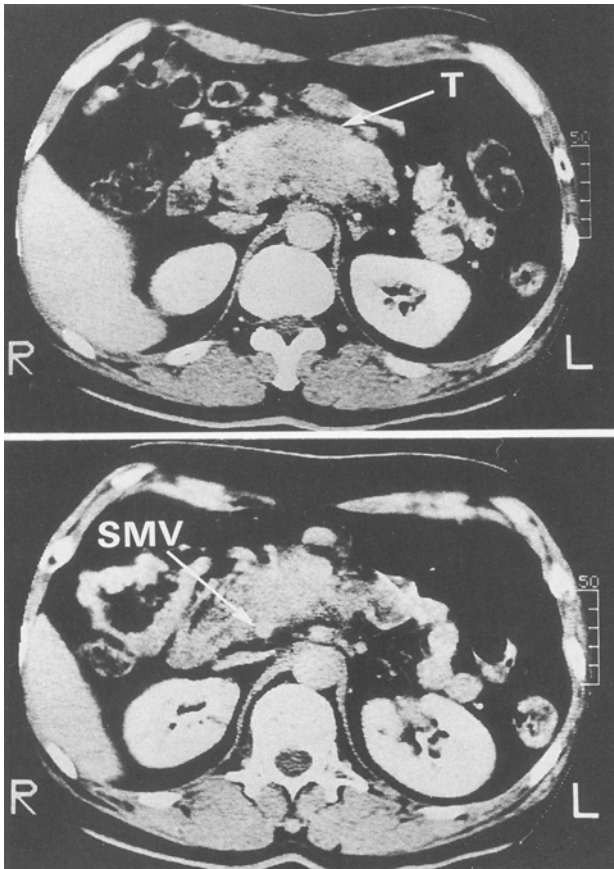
Abdominal computed tomography with contrast enhancement demonstrated a huge mass (*T*) in the body of the pancreas, without visualization of the portal vein. *SMV*, Superior mesenteric vein
